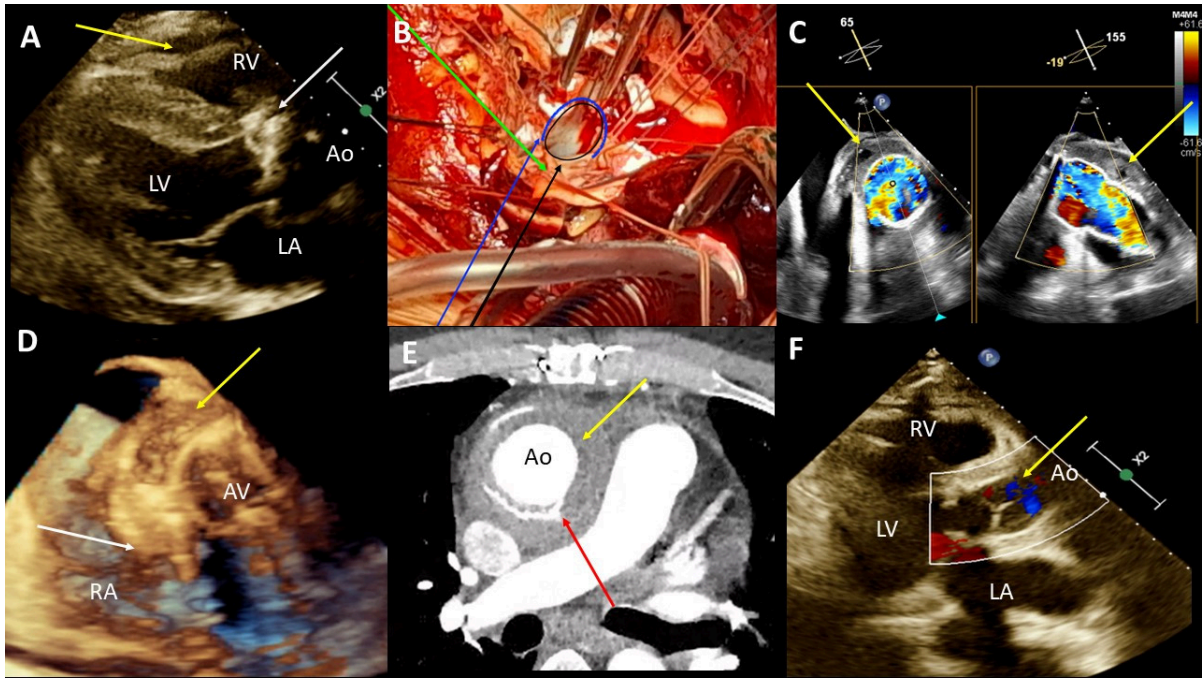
A. An abnormal image of the aortic valve and enlarged aortic bulb (white arrow); pericardial fluid (yellow arrow); 2D transthoracic echocardiography; a long axis view. B. An intraoperative view: left ventricle outflow tract (LVOT) — black line and arrow, 2/3 of the detached circumference of the aorta — blue line and arrow, ostium of the left coronary artery — green arrow. C. Perivalvular and periaortic infiltration with abscess cavities (yellow arrows); 2-dimensional transoesophageal echocardiography, X-plane view, color Doppler. D. Perivalvular infiltration with abscess cavities (yellow arrow) and a large bifurcated vegetation attached at its lower edge (white arrow); 3-dimensional transoesophageal echocardiography. E. An active periprosthetic leak (red arrow) and an extensive cuff indicating a periaortic hematoma (yellow arrow); contrast-enhanced computed tomography. F. A follow-up echocardiogram after aortic homograft implantation (arrow); 2D transthoracic echocardiography, color Doppler, a long axis view
